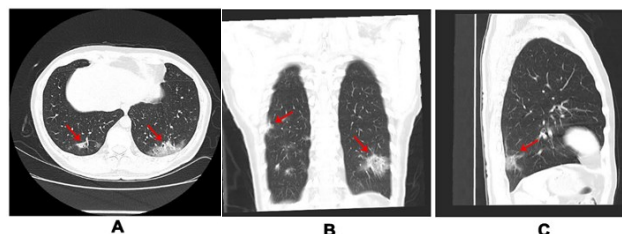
CT scans of a 35-year-old male presenting with fever, cough, headache, reduced lymphocyte count, and normal white blood cell count, neutrophil count and CRP level. A-C: Scans showing multiple lung lesions with a peripheral distribution, visible ground-glass density shadow, grid-like changes, subpleural signs, and thickening and deformation of bronchial and vascular branches. CRP: C-reactive protein.
